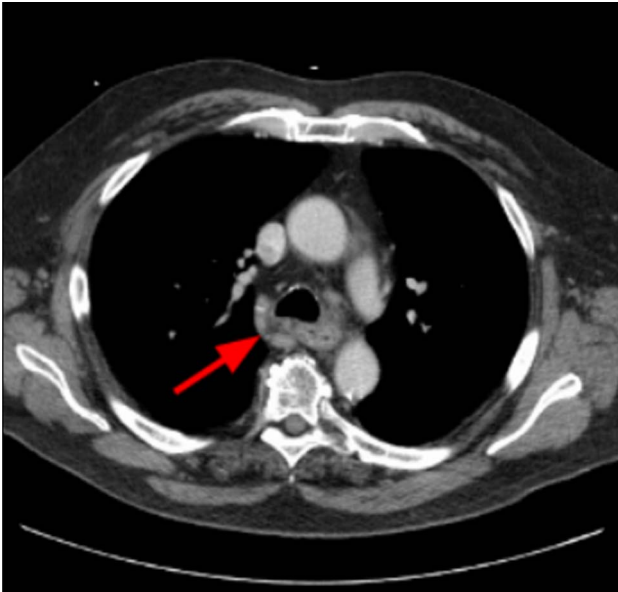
Chest CT with an irregular, circumferential esophageal mass (red arrow). CT, computed tomography.
